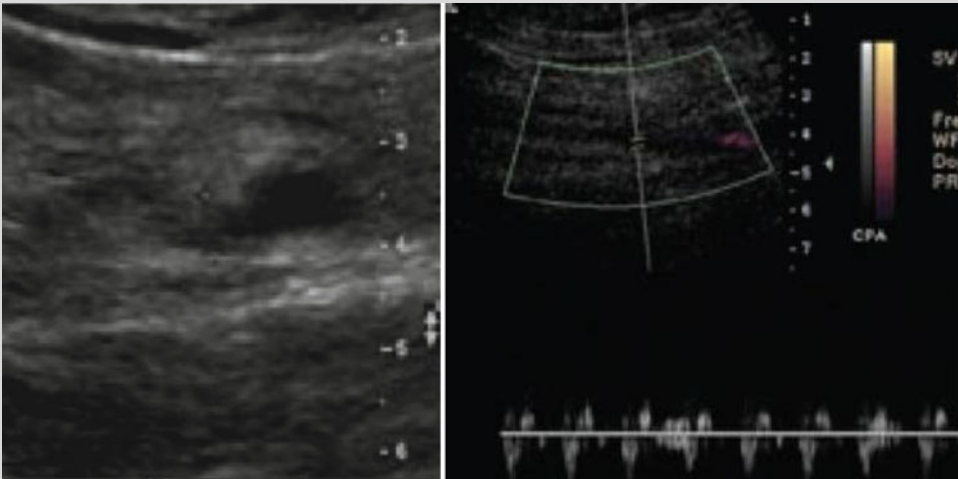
Left lower extremity Doppler ultrasound
